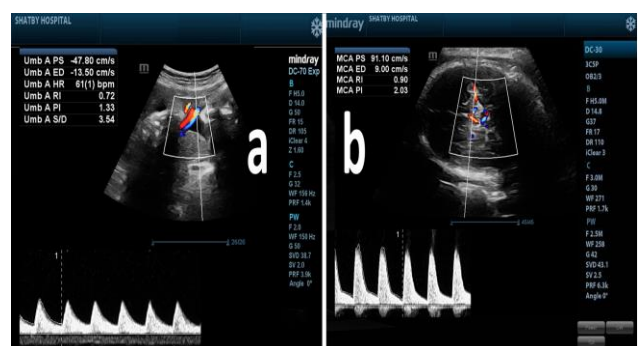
Doppler interrogation of (a) umbilical artery (UA) and (b) middle cerebral artery (MCA).
